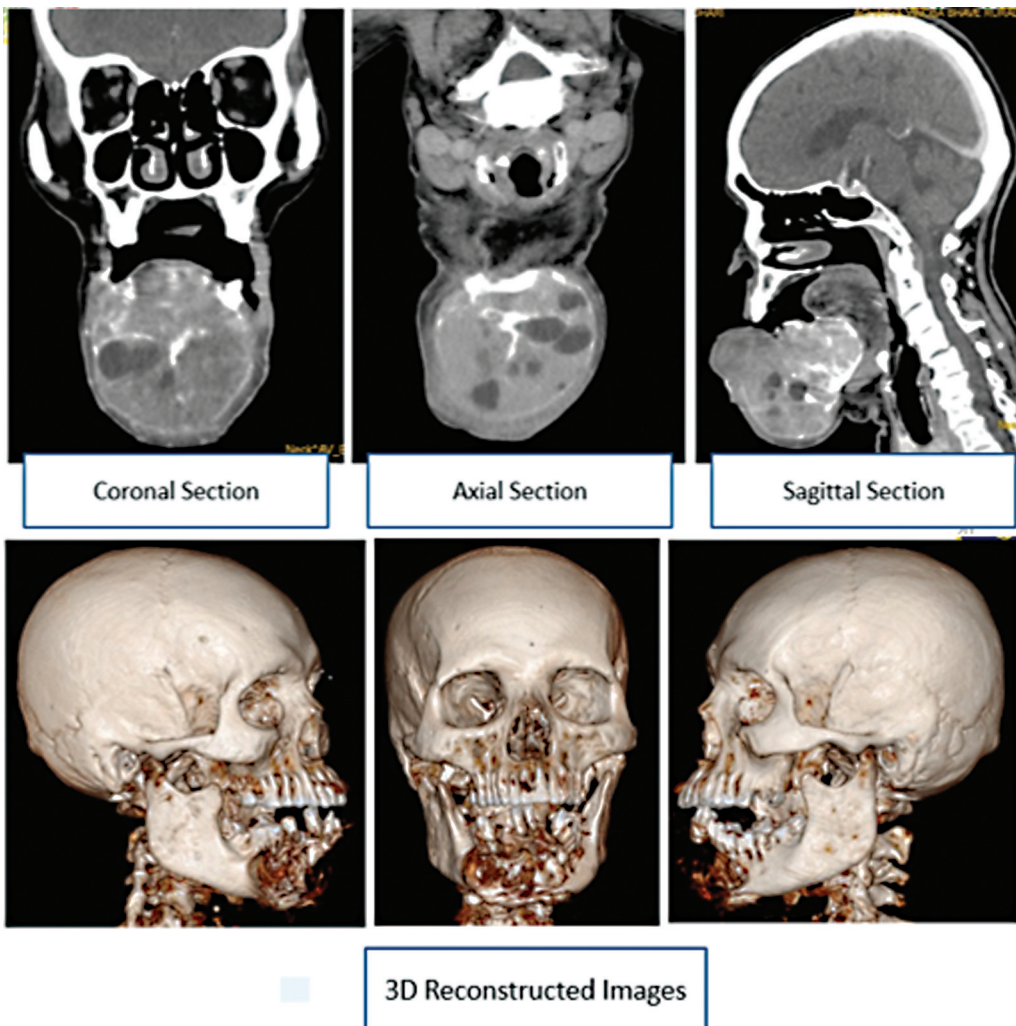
Computed tomographic scan showing coronal, axial, and sagittal sections.
